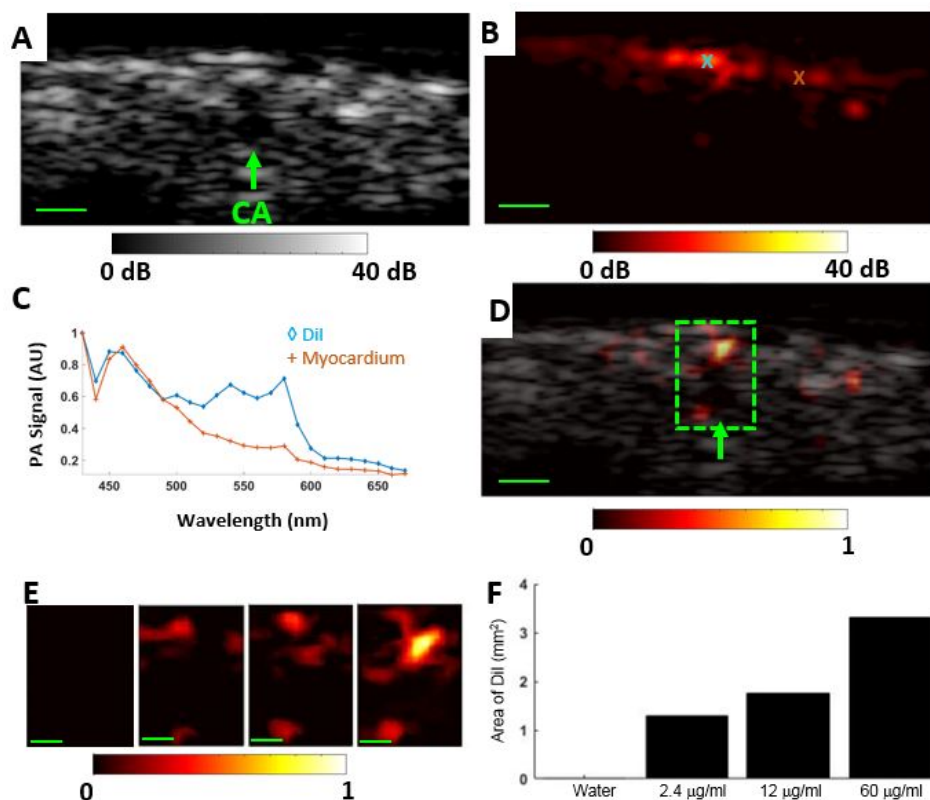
Estimation of DiI diffusion in the heart near the LADCA. (A) Cross sectional PE ultrasound image over LADCA. (B) Co-registered PA image at 550 nm with a dynamic range of 40 dB. The PA spectra over regions of interest marked with “X” are displayed in (C). Brown and blue regions are similar to the known absorption spectra of the myocardium and DiI, respectively. (D) Co-registered PE (gray) and unmixed PA signal for 60 µg/ml DiI concentration (following flush). Green box identifies the ROI for cumulative diffusion analysis. E) PA images over ROI (green box) for DiI concentration of 0 µg/ml (100% water), 2.4 µg/ml, 12 µg/ml, and 60 µg/ml. f) Diffusion area for each concentration based on PA signal over background. Scale bar is 2 mm.
